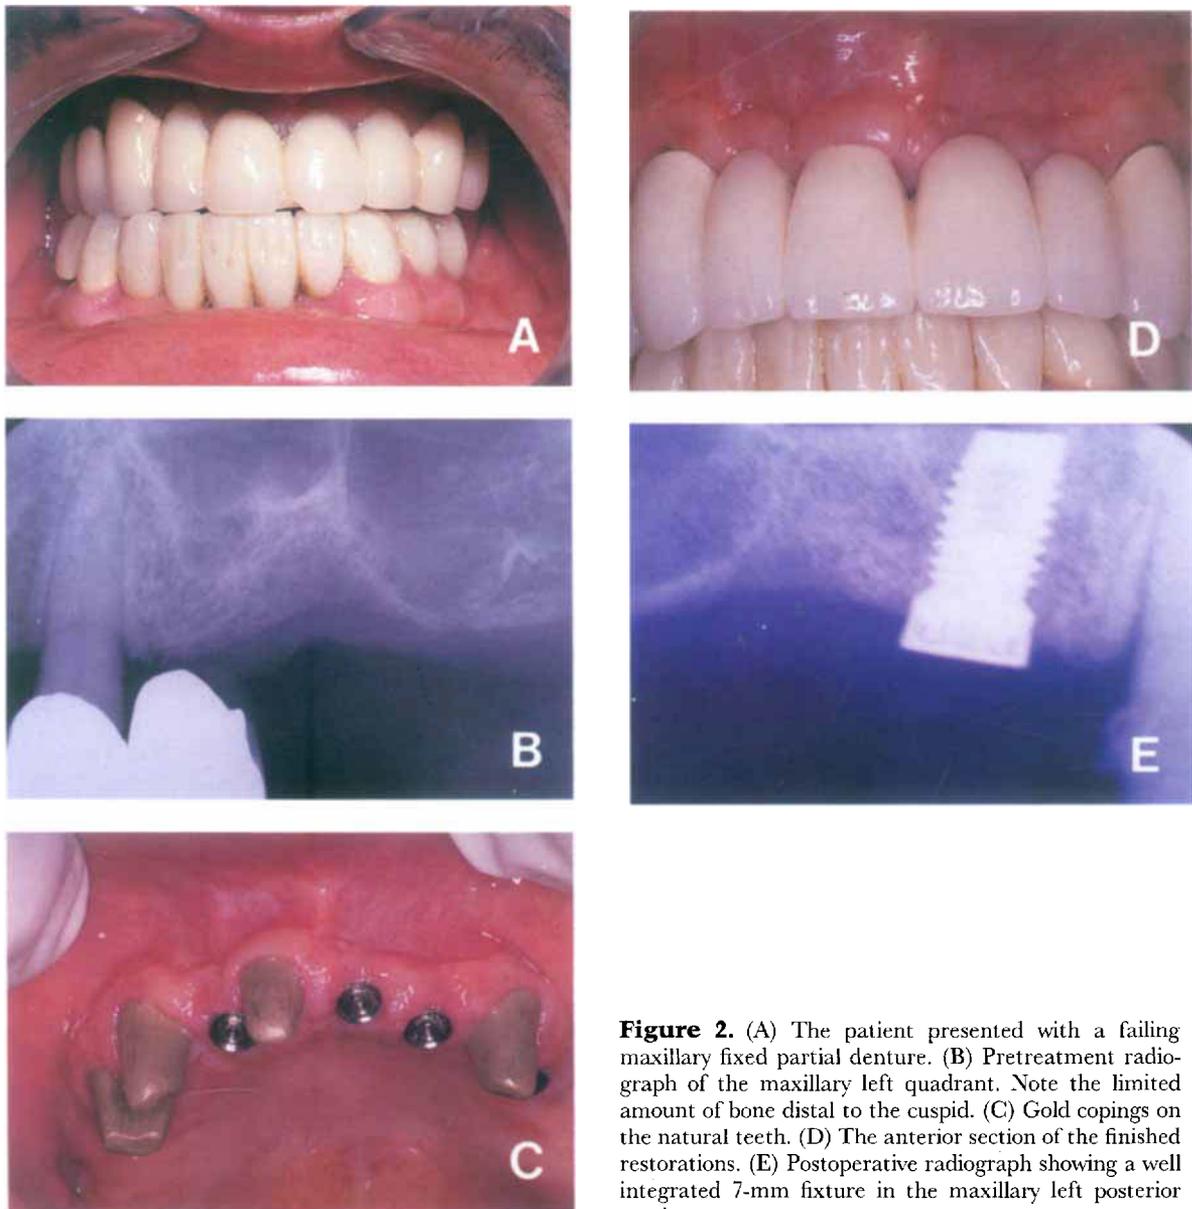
(A) The patient presented with a failing maxillary fixed partial denture. (B) Pretreatment radiograph of the maxillary left quadrant. Note the limited amount of bone distal to the cuspid. (C) Gold copings on the natural teeth. (D) The anterior section of the finished restorations. (E) Postoperative radiograph showing a well integrated 7-mm fixture in the maxillary left posterior quadrant.
